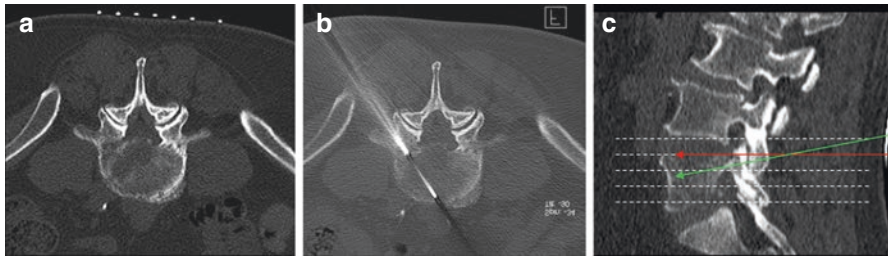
Common pitfall in CT-guided biopsy of vertebral body: during biopsy of a pathological fracture of the L5 vertebral body, axial localizing scans were acquired, and a slice was chosen as access-slice where both pedicle and vertebral body were visible (a). Results of the biopsy through the soft-tissue density area thought to be in the vertebral body (b) returned as disc material and cartilage. Review of the procedure showed that the axial localizing scan, acquired with no gantry tilt (dashed white lines on c), was not respective of the lordotic position of the L5 vertebra, and although the access was through the pedicle, the biopsy most likely was through the L4–L5 disc space (red arrow on c). A repeat biopsy, with gantry tilt, guided the biopsy through the pedicle and the L5 vertebral body (green arrow on c), resulting in the diagnosis of metastases from renal cell cancer
